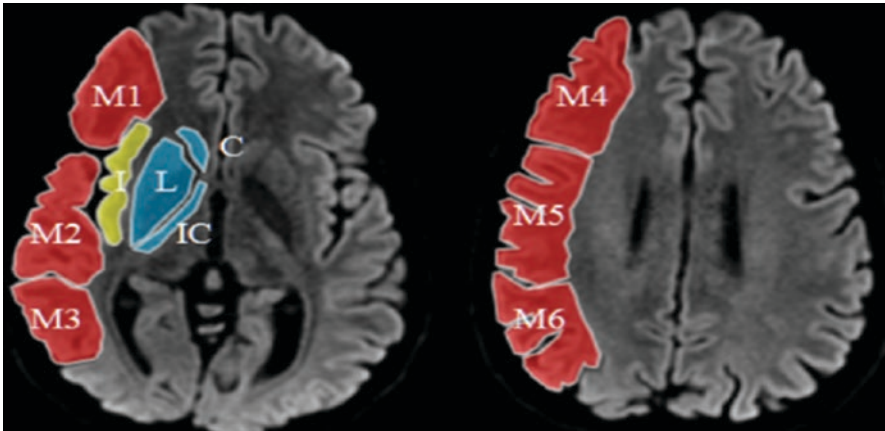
Calculate Alberta stroke program early CT score
